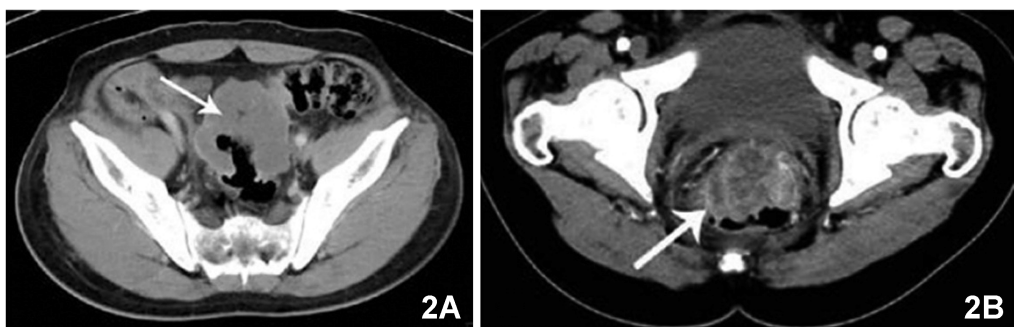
CT of RMAC and NMAC<sup>[45]</sup>
